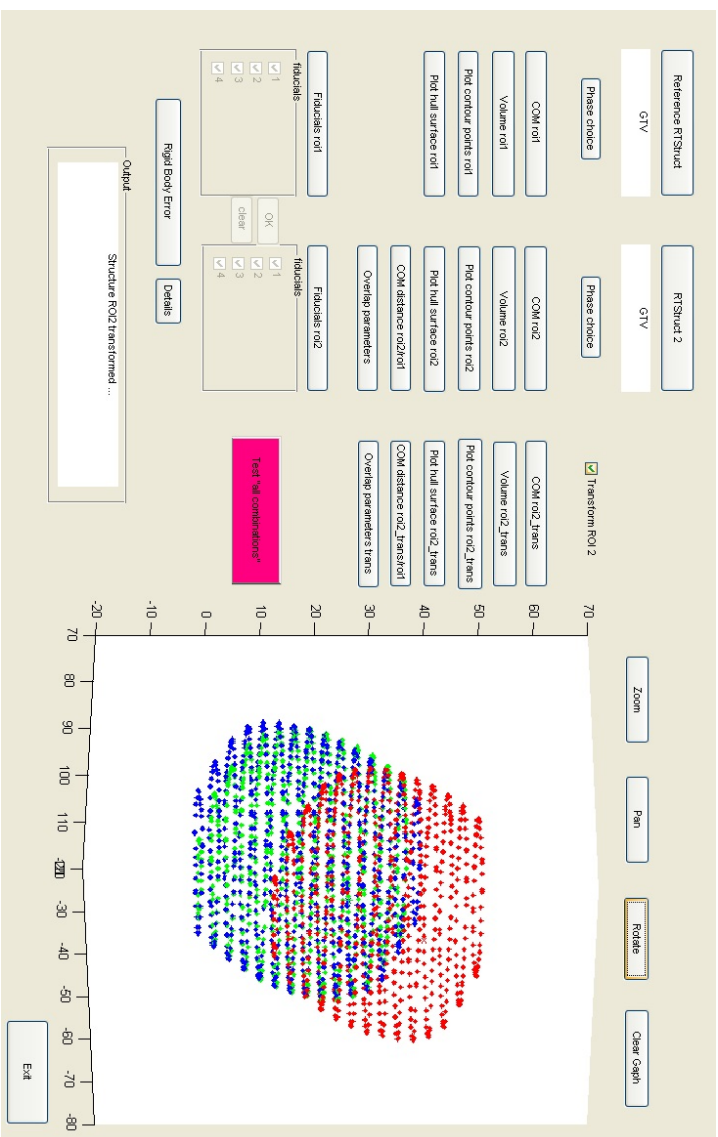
Graphical User Interface (GUI) encoded in Matlab. This GUI allows both registering two structures using different registration modes and calculating specific overlap parameters. The green contours are the result of the registration of the red to the blue structure based on the fiducials location. The structures of the CT without and with contrast product correspond to the blue and red contours respectively
